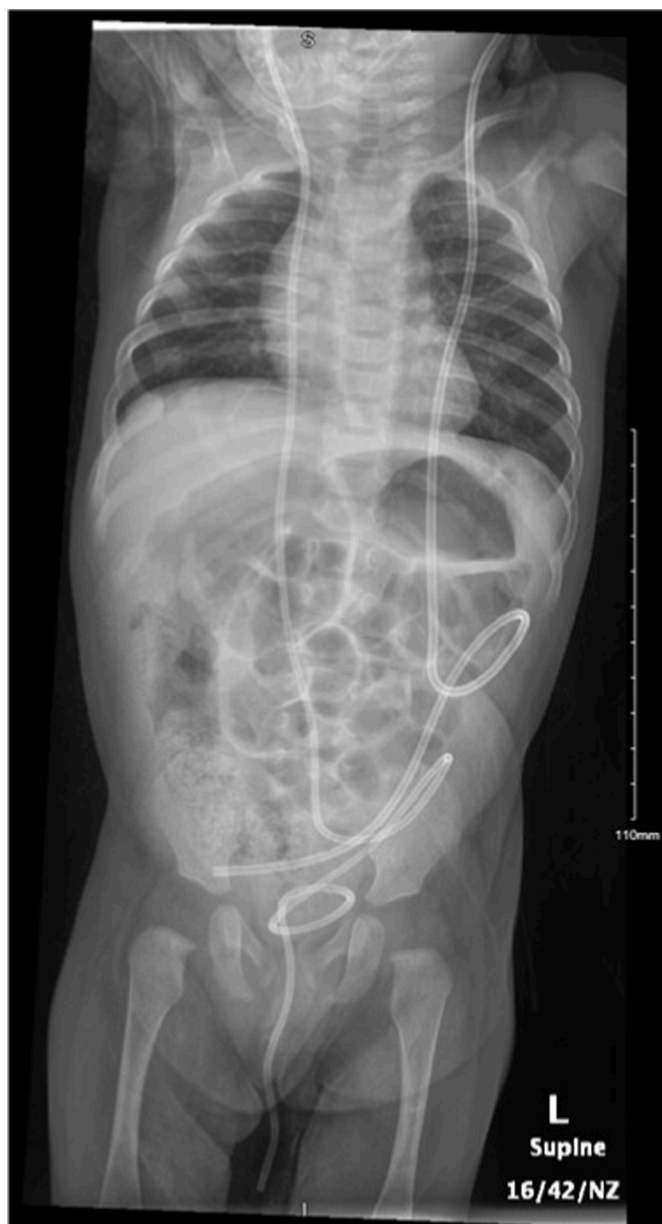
Shunt survey X-ray demonstrating the peritoneal end of the right VP shunt traversing through the abdomen, and outside the pelvis, likely through the urethra.
